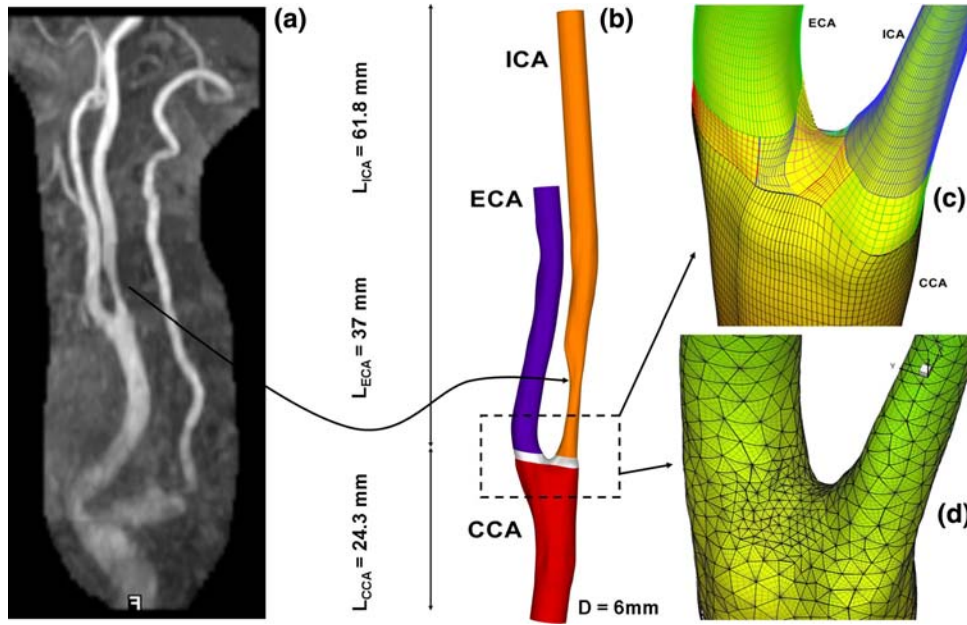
(in color) Reconstruction of arterial geometry from MRI images: (a) MRI of carotid artery (courtesy of Prof. M. Gomori, Hadassah, Jerusalem). (b) Geometrical model of a carotid artery; colors represent different arterial segments. (c) Patches of parametric surface representation, colors represent different patches. (d) Computational mesh, consistent with third-order polynomial approximation.
